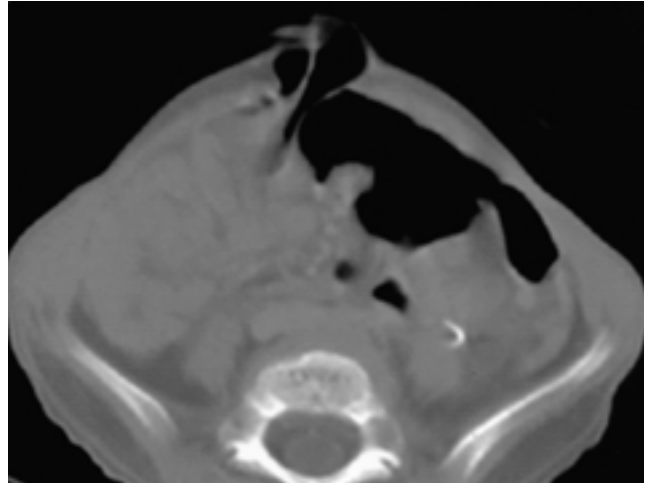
8-year-old boy with Hunter syndrome. Abdominal CT scan shows umbilical hernia.
